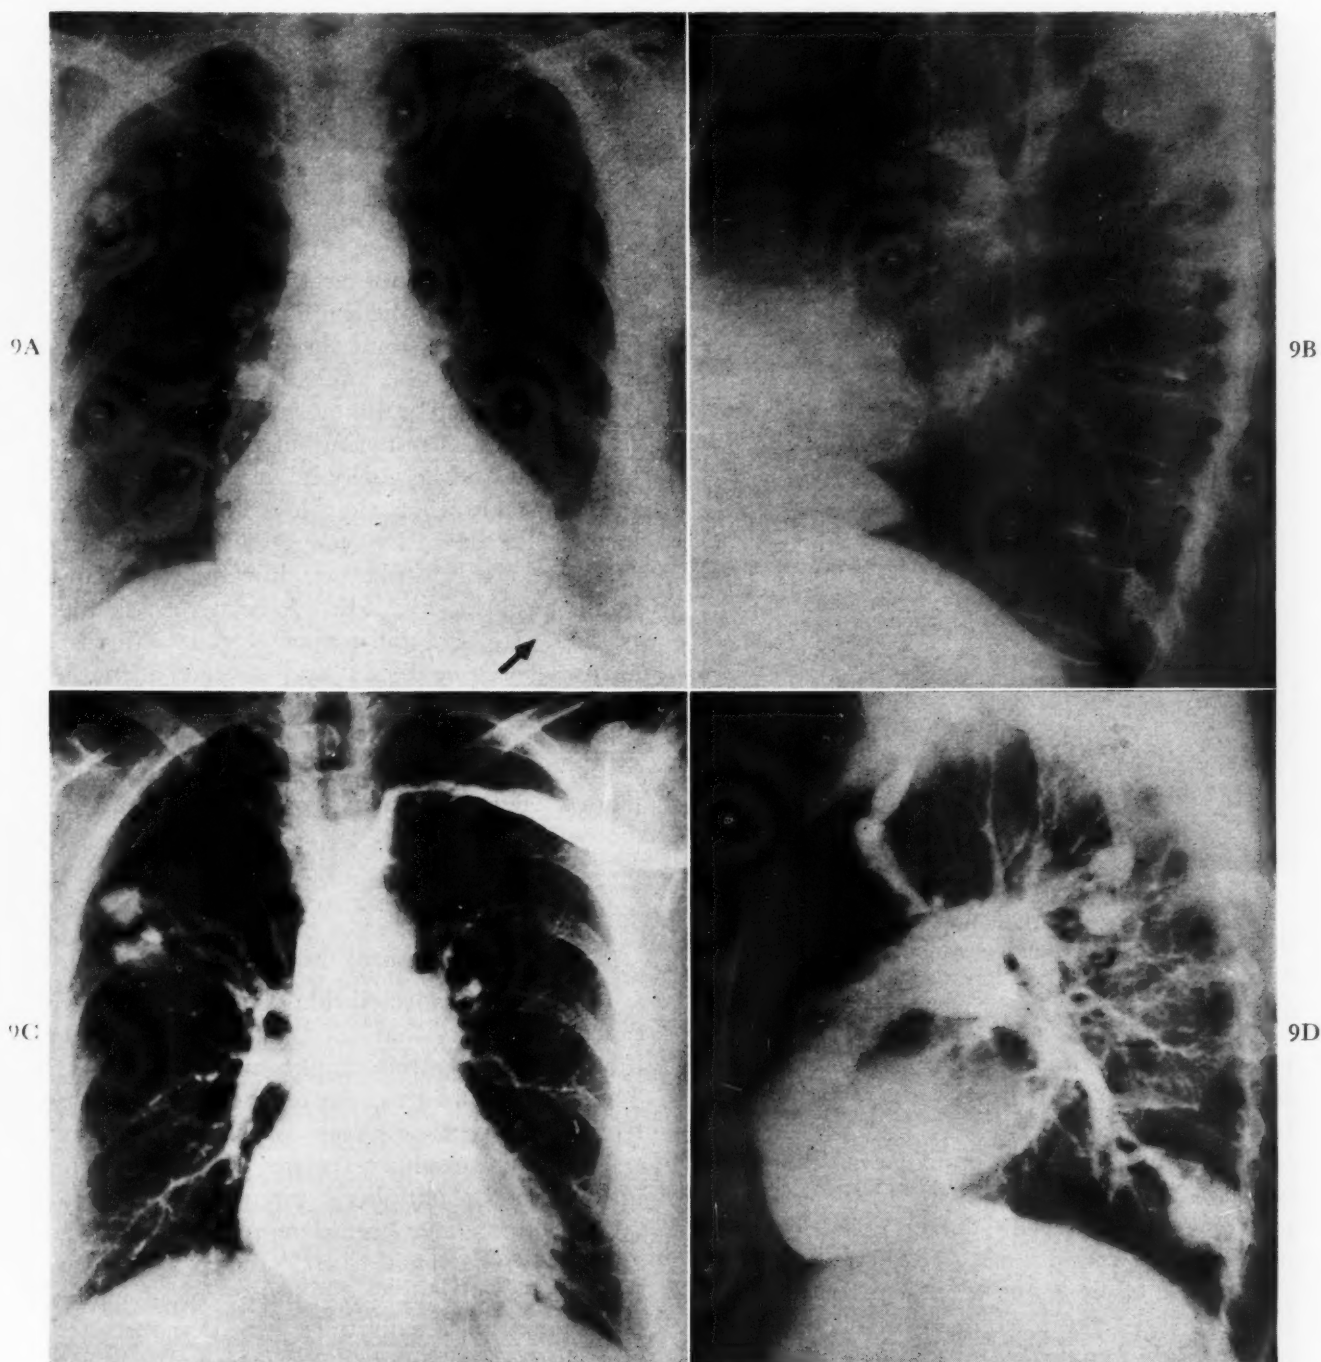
Case IX. Pulmonary arteriovenous fistulas of the posterior segment right upper lobe and posterior basilar segment of the left lower lobe. A, conventional frontal x-ray shows two rounded opacities in the right upper lobe with hilar connecting afferent and efferent blood vessels. Left lower lobe lesion obscured by heart and diaphragm (arrow). B, lateral, shows the posterior location of the upper lobe densities and another large rounded mass at the base. C, frontal angiogram demonstrates the bilateral pulmonary arteriovenous fistulas. D, lateral angiogram reveals the segmental and posterior location of the fistulas.
